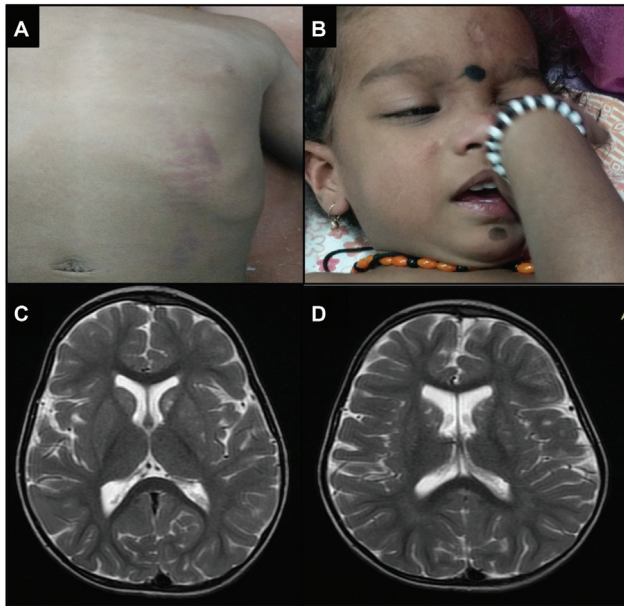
(A,B) Clinical photograph showing ecchymosis and purpuric lesion over the trunk and faces. (C,D) MRI of the brain showing symmetrical heterogenous hyperintensities in the caudate and putamen.
